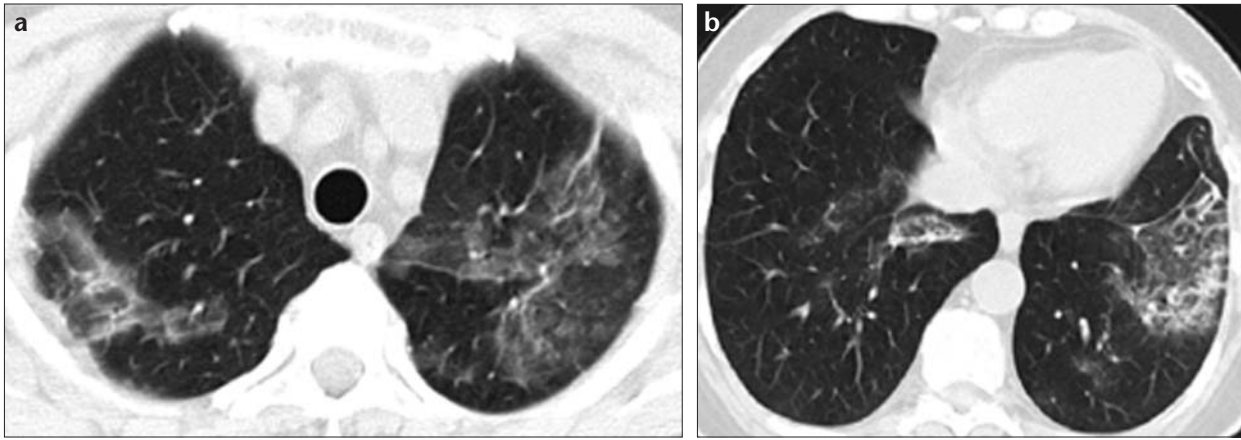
a, b. Twentieth day follow-up CT scan after tapering steroid dose shows ground glass densities that become more widely spread (a) and new ground glass opacities are seen at the lower lobes bilaterally (b).
